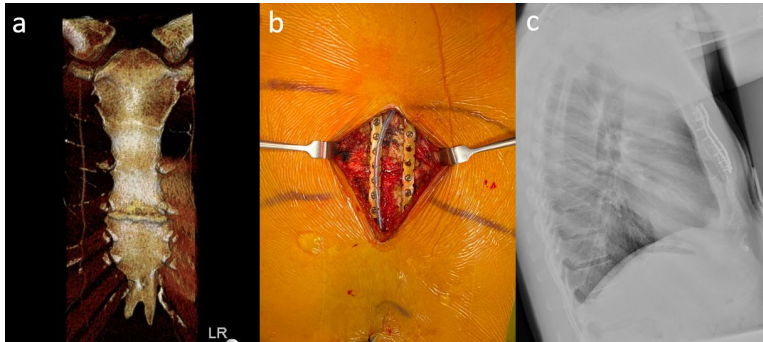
a) Pre-operative computed tomography of sternum, b) Intra-operative imaging of sternal plates, c) Lateral chest x-ray post-operatively
